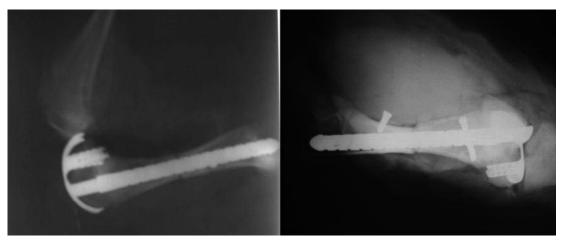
Postoperative X-ray examination at stage I.
